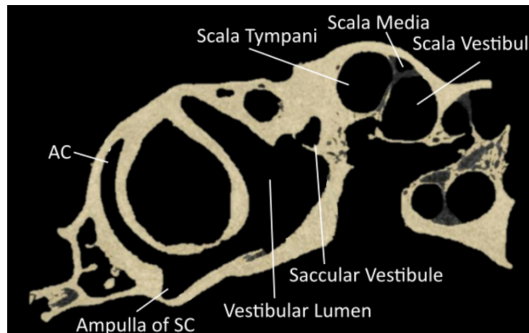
Segmented  $\mu$ CT scan in the sagittal plane of the chinchilla subject with key structures labeled. See Table 3 for symbol definitions.
